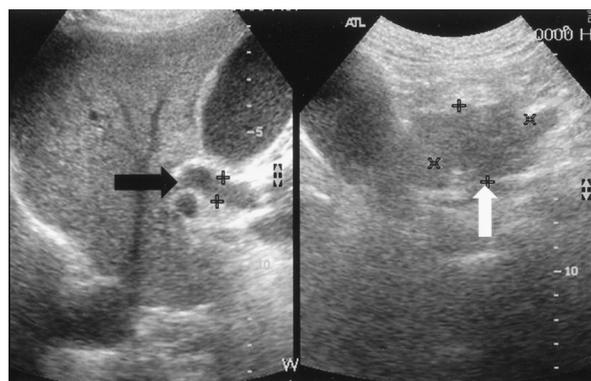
Trans-abdominal ultrasound disclosed fatty liver, gallbladder sludge, dilated common bile duct (black arrow) and a 4.0 x 3.3 cm hypoechoic lesion in the pancreatic head (white arrow).
